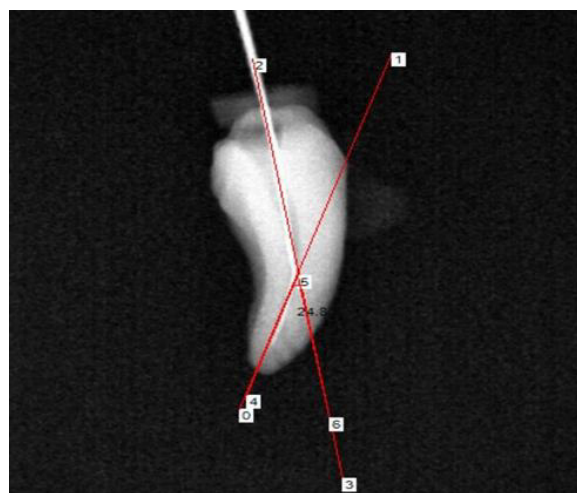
Initial Radiograph measuring canal angle
